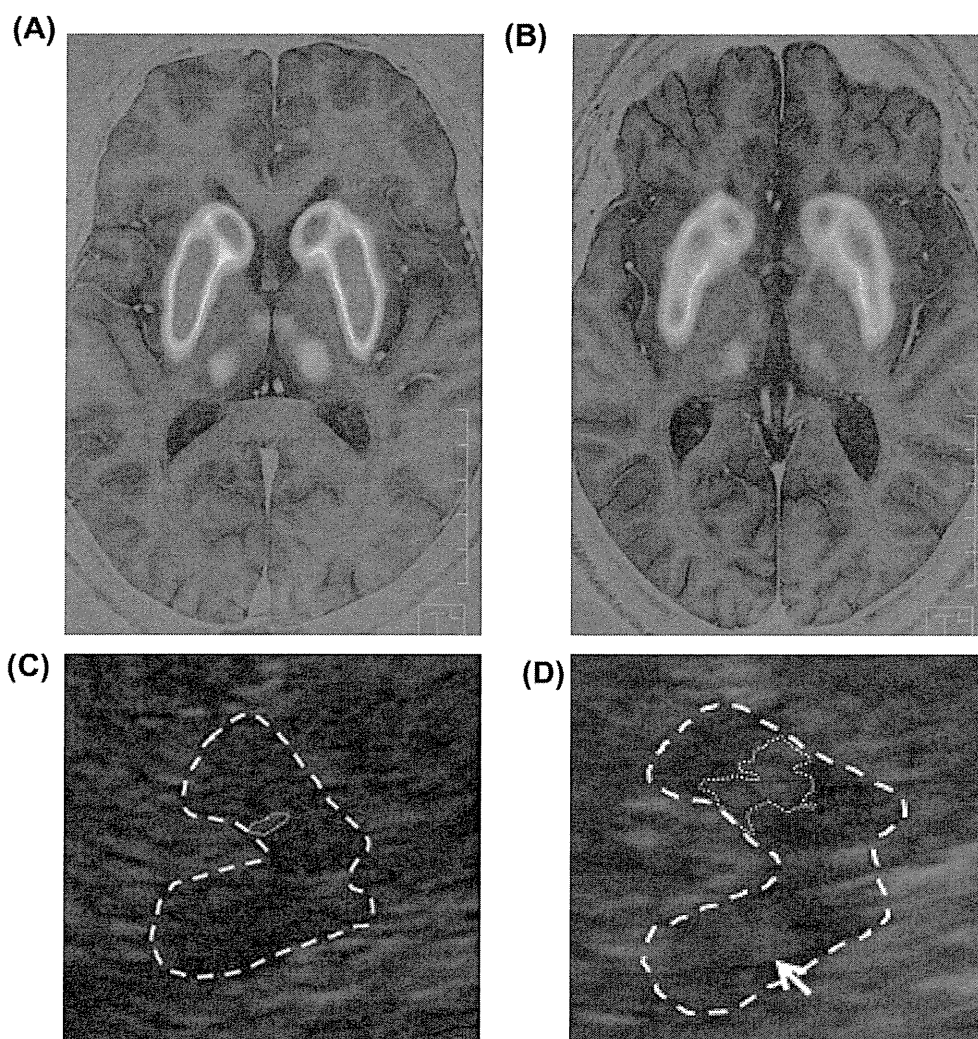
(A) 6- ^{18}F Fluoro-meta-tyrosine positron emission tomography (6- ^{18}F)FMT PET on magnetic resonance imaging (MRI). This demonstrates preserved dopamine terminals in the caudate and putamen in a healthy subject. (B) 6- ^{18}F)FMT PET on MRI. This demonstrates patchy decreased dopamine terminals in the caudate and putamen in a patient with idiopathic rapid eye movement sleep behaviour disorder (iRBD). (C) Transcranial sonography (TCS) of bilateral substantia nigra (SN) hyperechogenicity in a healthy subject. The area of hyperechogenic SN signal within the hypo-echogenic crus cerebri is encircled on the ipsilateral side for planimetric measurement (0.10 cm²). (D) TCS of bilateral SN hyperechogenicity in a patient with iRBD. The area of the hyperechogenic SN signal within the hypo-echogenic crus cerebri is encircled on the ipsilateral side for planimetric measurement (0.44 cm²).
